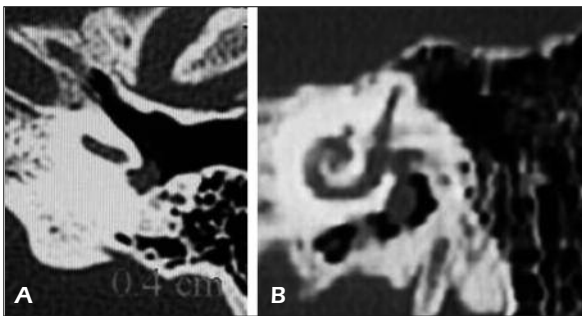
A, B, CT, axial plane Small soft tissue mass involving the promontory and the round window niche. Maximum diameter of the mass in the middle ear is 0.4.
